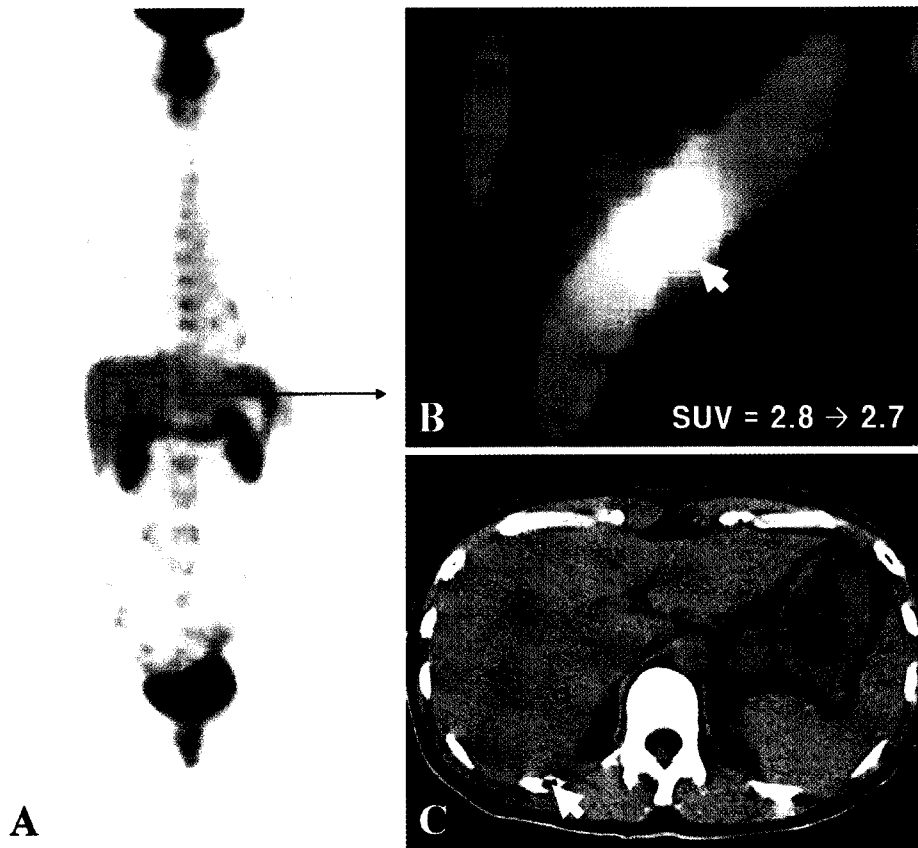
(A) Maximum intensity projection PET/CT of the torso shows a spotty area of mild FDG uptake in the right lowermost rib (framed). (B) Magnified coronal PET/CT scan shows the lesion with increased FDG uptake (arrow). (C) Transverse CT section shows a small lytic lesion (arrow).
